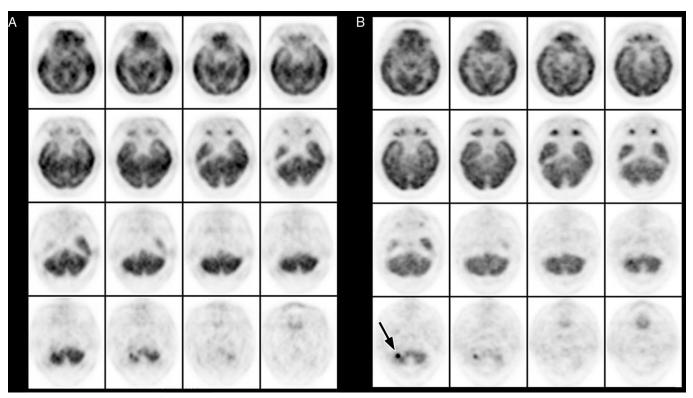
A 50-year-old man had an osteosarcoma in the right occipital bone near the jugular foramen, and had been treated with surgical removal of the tumor and subsequent adjuvant chemotherapy. Six months after the treatment, residual tumor was still suspected during the clinical follow-up. His attending clinician asked for an FDG PET/CT scan for further evaluation. After 50 minutes of the intravenous administration of 444 MBq (12 mCi) FDG, an early phase PET/CT scan was acquired using a General Electric Discovery LightSpeed PET/CT hybrid imaging scanner. There was no obvious abnormal FDG radioactivity in the right occipital bone region, but relatively normal physiological distribution of the adjacent brain radioactivity on the early phase images (Panel A, representative transaxial slices). For tumor survey, a routine delayed-phase scan of the head (Panel B, representative transaxial slices) was acquired at 180 minutes after the administration of FDG. Surprisingly, a distinct small area of focal intense radioactivity emerged from the prior normal-looking right occipital bone/adjacent brain area (black arrow).
